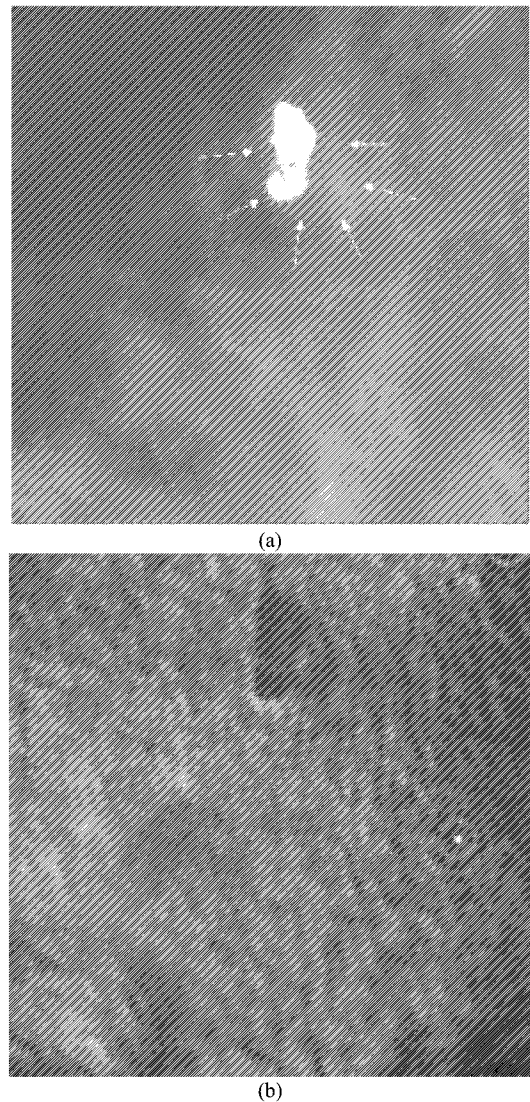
The breast image with fibro adenoma: (a) Marked x-ray by radiologist showing the fibro adenoma and the nearby calcification; (b) The VA image of the same subject.
